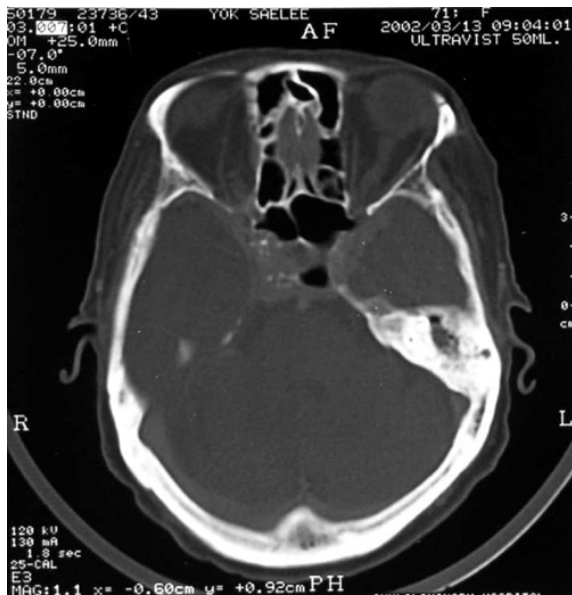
CT of the brain (Bone window) showed bony erosion of the dorsum sellae and anterior clinoid processes
